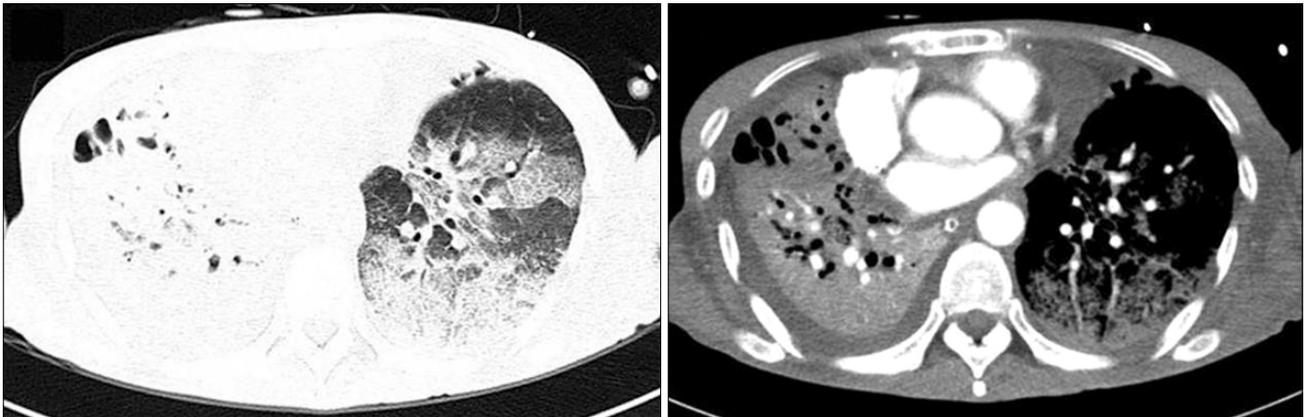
A chest CT scan obtained on second hospital day showed extensive consolidation and ground glass opacities on left lower lobes and atelectasis on right lower lobe.
